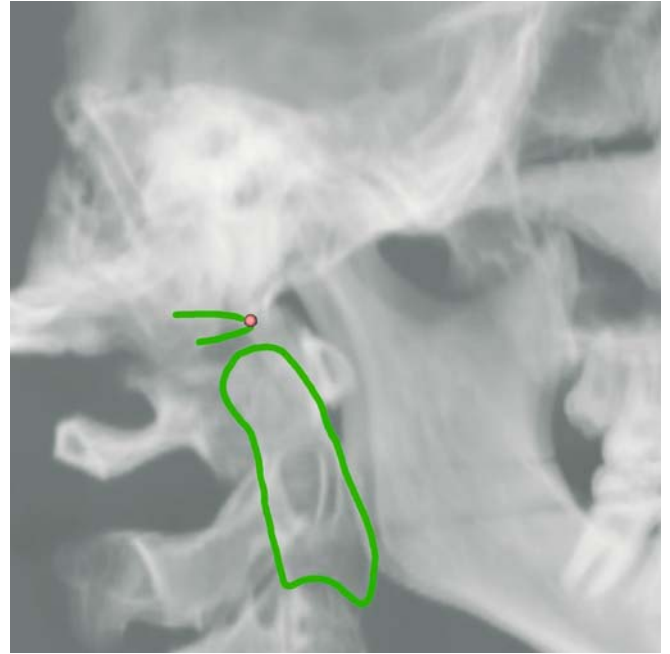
Basion. Virtual lateral cephalogram (3-D CT, patient K.C.)
